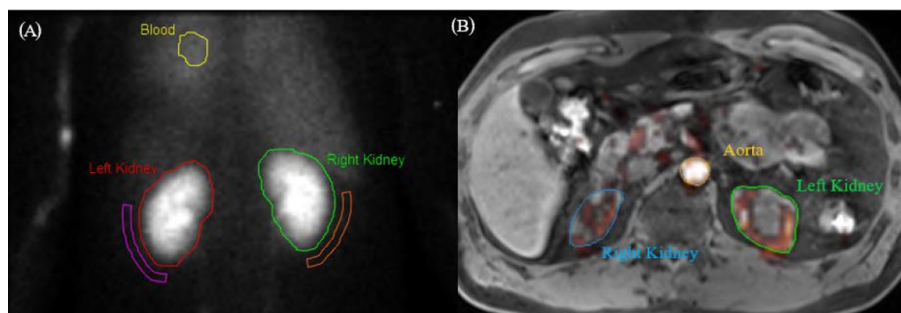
A MAG_3 regions of interest (ROIs) over the heart for blood input function, whole left and right kidneys, and their respective backgrounds. B MRI T1 and PET images, fused at the FDG peak activity within the aorta. ROIs are manually delineated for the aorta, left kidney, and right kidney
